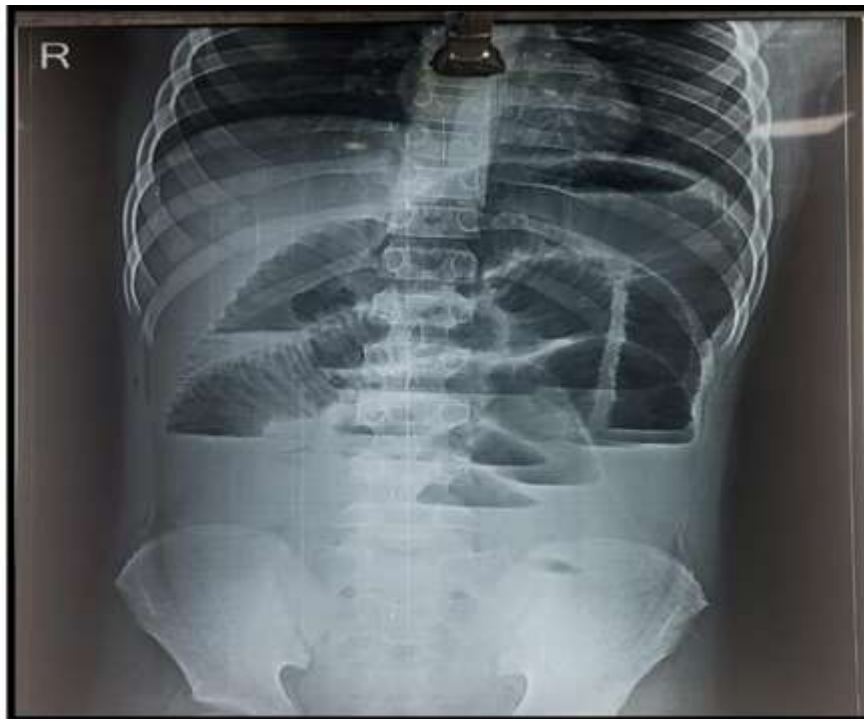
Abdominal erect X-ray showing multiple air fluidlevel- IO
